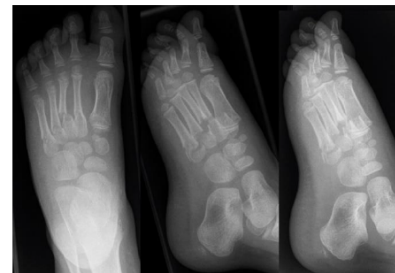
X-ray at admission.
